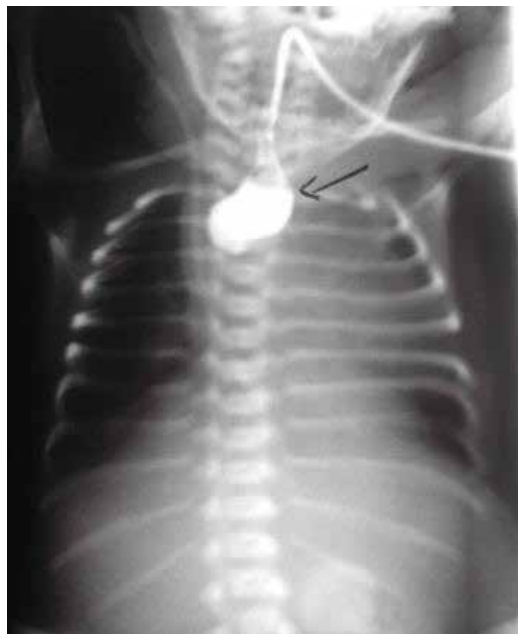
Simple thoracic X-ray, revealing the fundus of the proximal sac contrasted with a water-soluble medium. This is an esophageal atresia type A.
